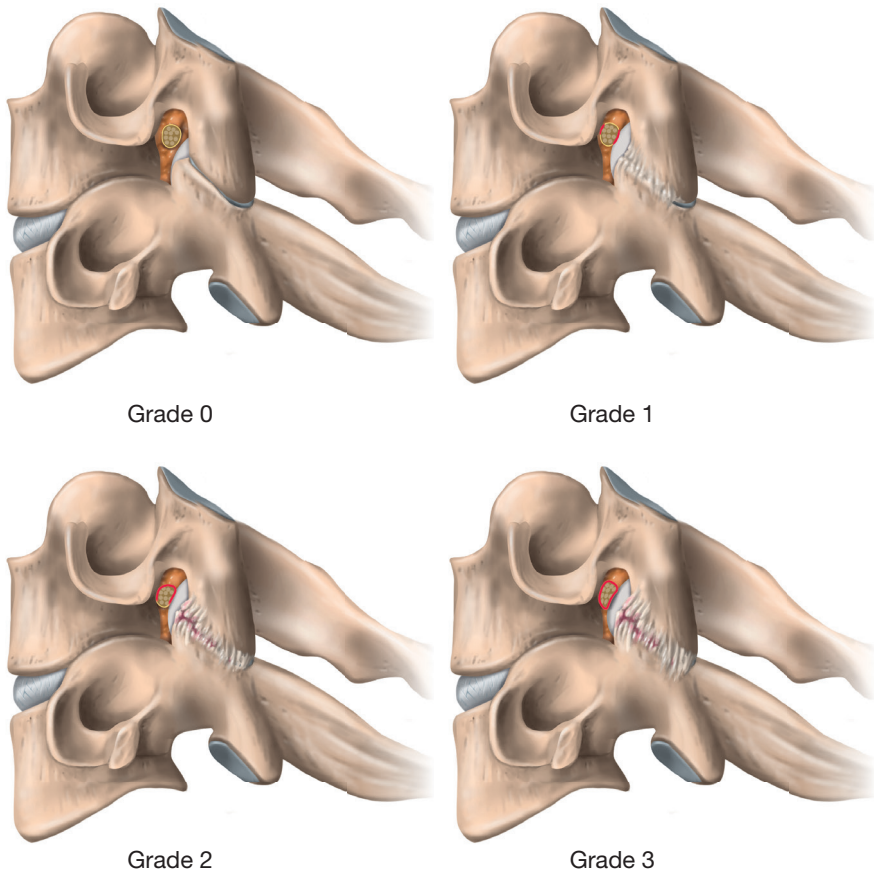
The Park system for classifying cervical foraminal stenosis from oblique sagittal MRI is outlined as follows: Grade 0 indicates no signs of stenosis or loss of perineural fat. Grade 1 shows less than 50% obliteration of perineural fat. Grade 2 is characterized by more than 50% obliteration of perineural fat. Lastly, Grade 3 presents with a nerve root that has collapsed morphologically.
